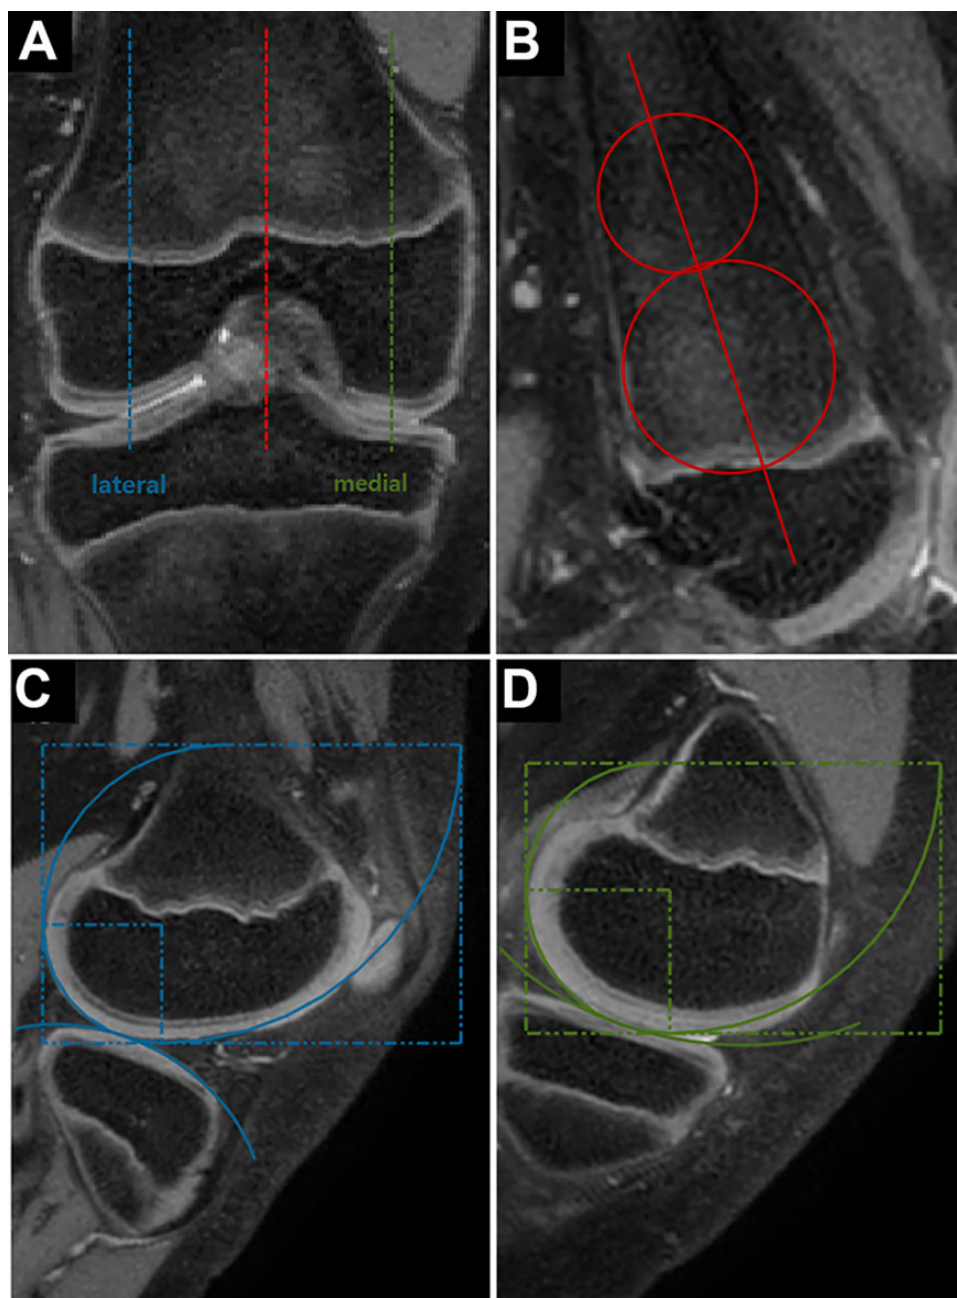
Measuring the femoral curvature on magnetic resonance imaging. (A) Three sagittal sections were created on the coronal plane of the femur: the middle section of the femur (dashed red line), the lateral condyle (dashed blue line), and the medial condyle (dashed green line). (B) On the sagittal section of the dashed red line in (A), the longitudinal femoral axis (solid red line) was determined by connecting the centers of 2 best-fit circles. (C) The lateral femoral curvature radii (solid blue lines) were determined using a Fibonacci spiral on the sagittal plane of the dashed blue line in (A). (D) The medial femoral curvature radii (solid green lines) were determined on the sagittal plane of the dashed green line in (A). The femoral lateral and medial anteroposterior lengths were also determined on the sagittal plane.
